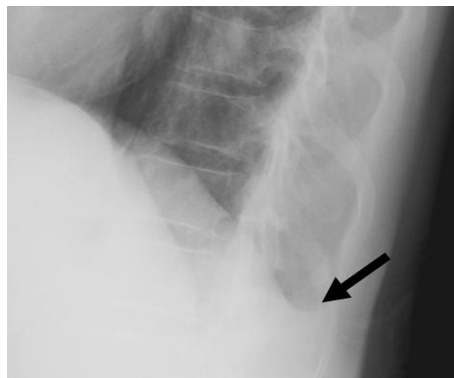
Chest CT (A) and lateral radiography (B) of a 78-year-old male patient
